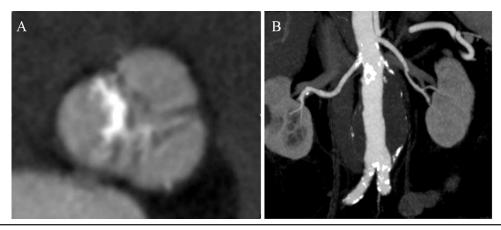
A, CT Scan of the Calcified Aortic Valve; B, CT Scan of the Abdominal Aortic Aneurysm
